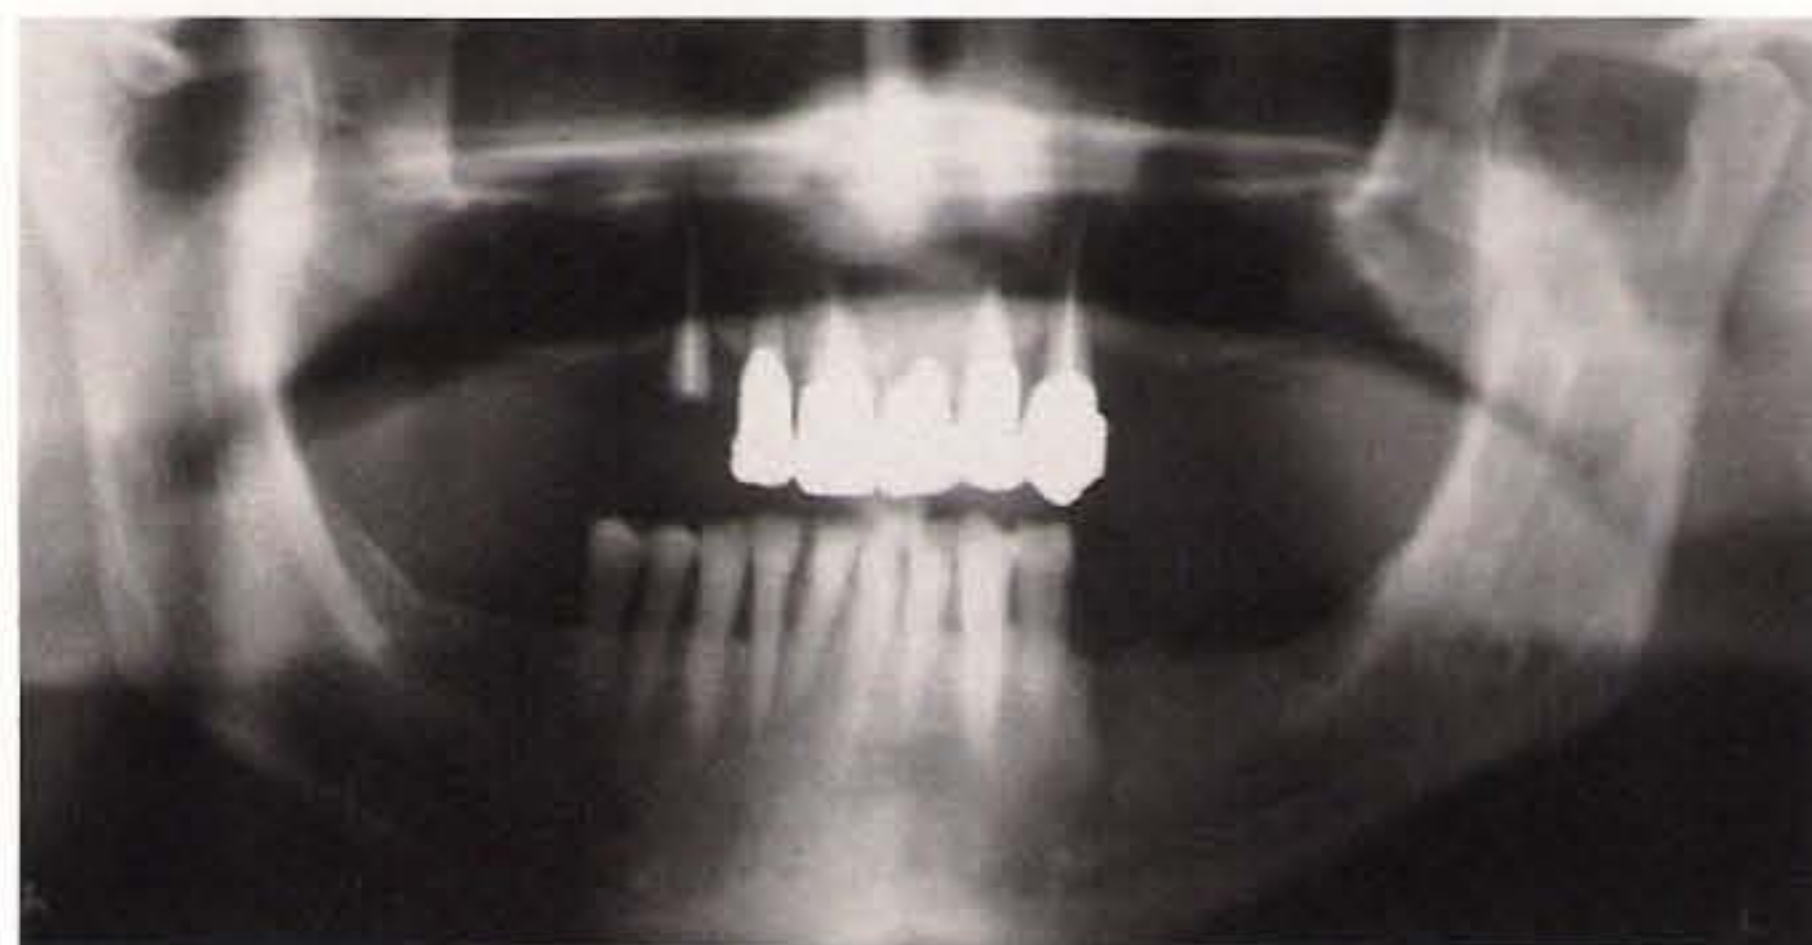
Initial panoramic radiograph revealing severe maxillary atrophy. The maxillary teeth must be extracted because they are gravely periodontally compromised.
